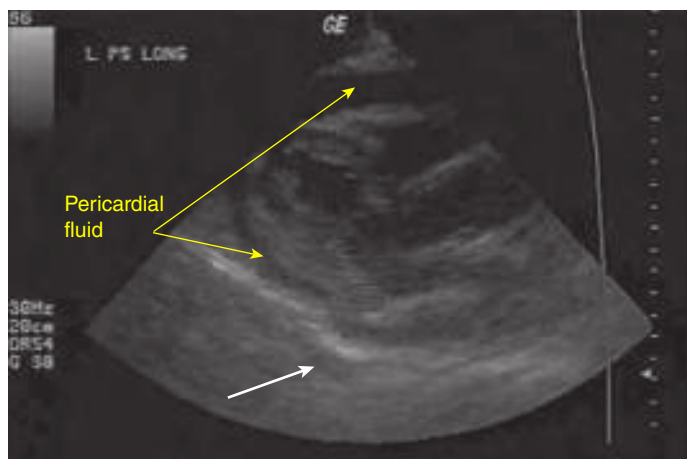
The parasternal long axis view of a pericardial effusion. Pericardial fluid separates the myocardium from the pericardium and the poorly visualized descending aorta (white arrow).
